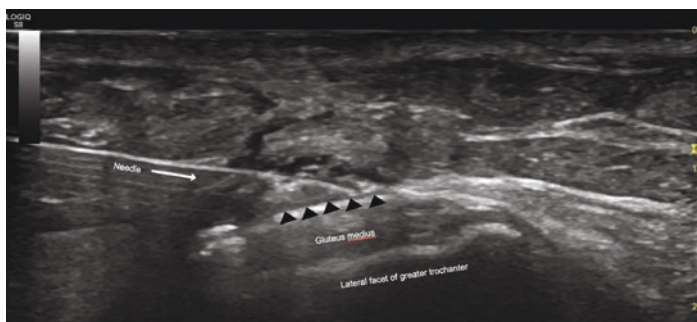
Example of corticosteroid injection into subgluteus maximus bursa under ultrasound guidance. (Arrowheads) outline the distended subgluteus maximus bursa
